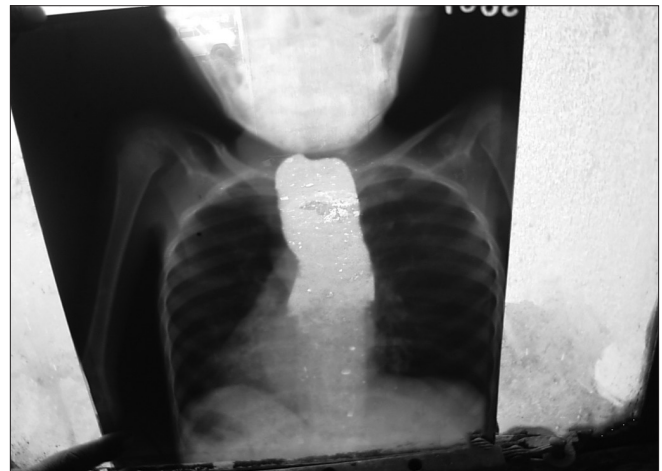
Chest X-ray showing achalasia cardia
